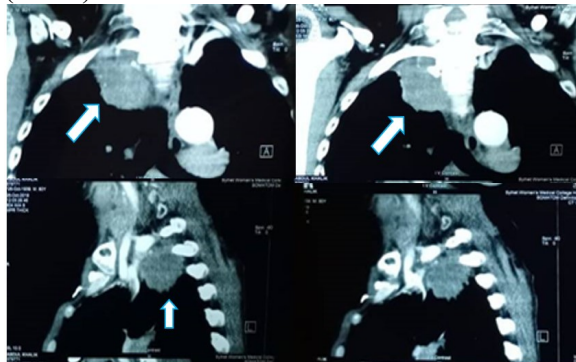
CT chest showing right apical mass (arrow)
